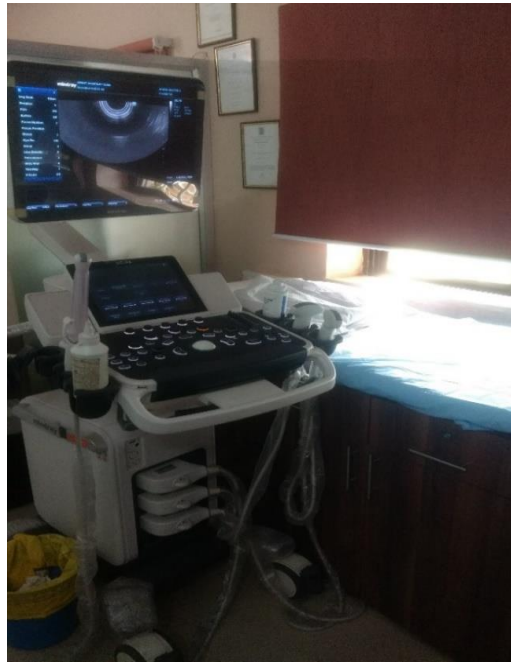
Ultrasound room, Infertility clinic B
